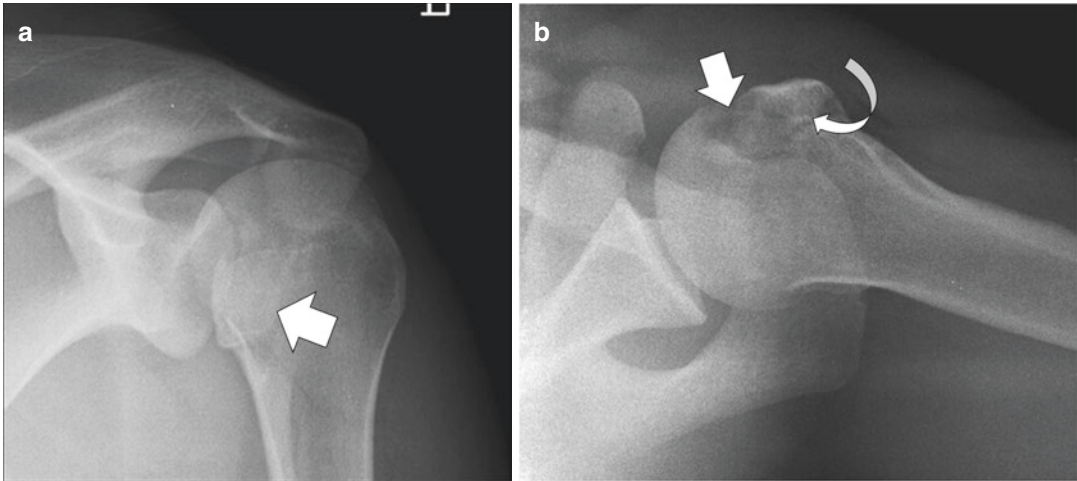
Lesser tuberosity fracture in a posterior shoulder dislocation. (a) Frontal radiograph shows that the humeral head is perched against the posterior glenoid rim and there is double density seen in the region of the lesser
